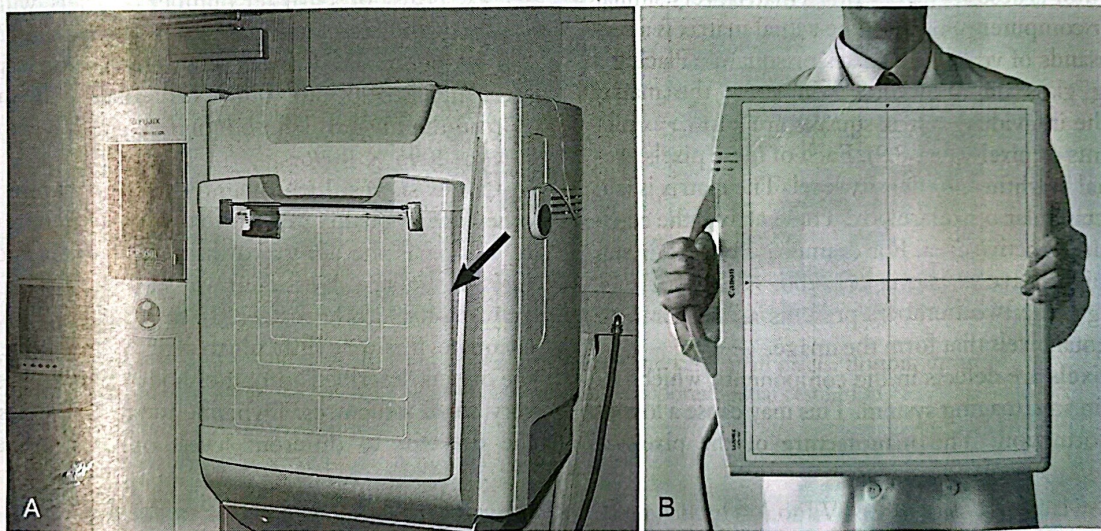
(A) An upright or wall-mounted digital radiography unit. The flat-panel detector is built into the front of the unit (*arrow*). This unit is used for radiography of upright chests and abdomens primarily but can be used for any x-ray projection that is done in the upright position. (B) A digital radiography (DR) cassette containing a flat-panel detector. These plates can be carried anywhere for obtaining fast images.
